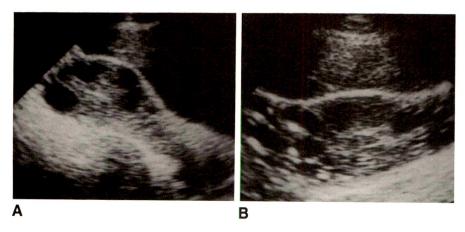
Real-time sonogram shows multiple anechoic spaces in the uterus (A) and in both adnexal regions (B).
